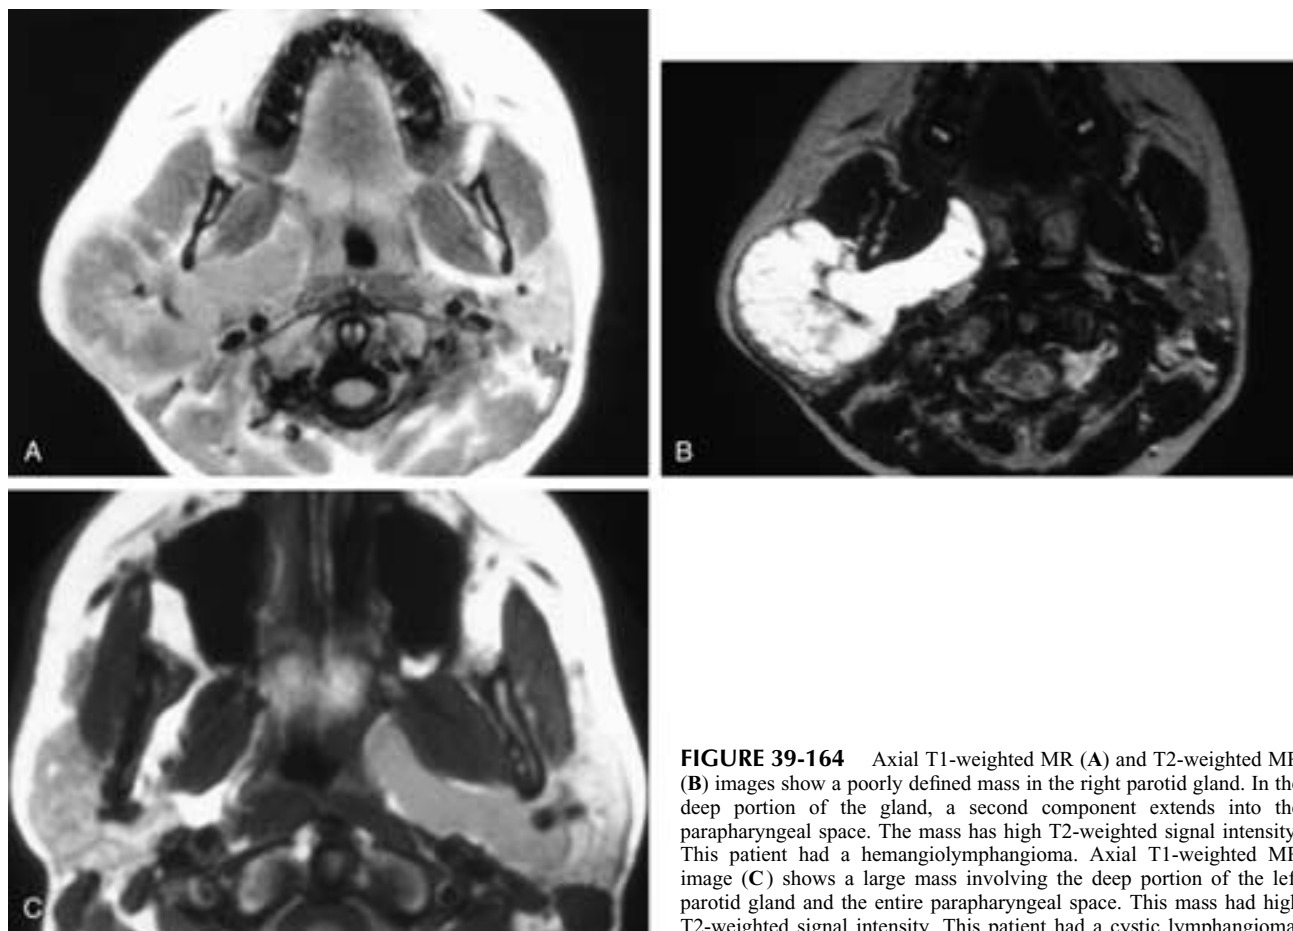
Axial T1-weighted MR (A) and T2-weighted MR (B) images show a poorly defined mass in the right parotid gland. In the deep portion of the gland, a second component extends into the parapharyngeal space. The mass has high T2-weighted signal intensity. This patient had a hemangiolympangioma. Axial T1-weighted MR image (C) shows a large mass involving the deep portion of the left parotid gland and the entire parapharyngeal space. This mass had high T2-weighted signal intensity. This patient had a cystic lymphangioma.
